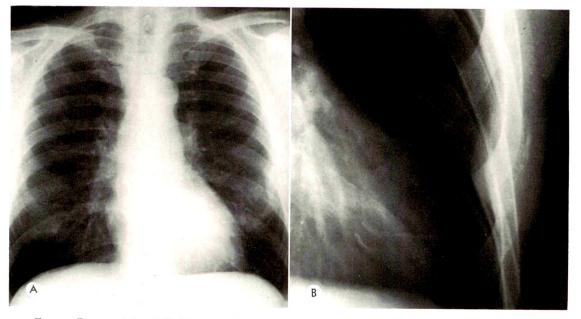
Case iv. (A and B) Preoperative chest roentgenograms reveal an osteolytic process of the left sixth rib with a localized extrapleural soft tissue mass.
